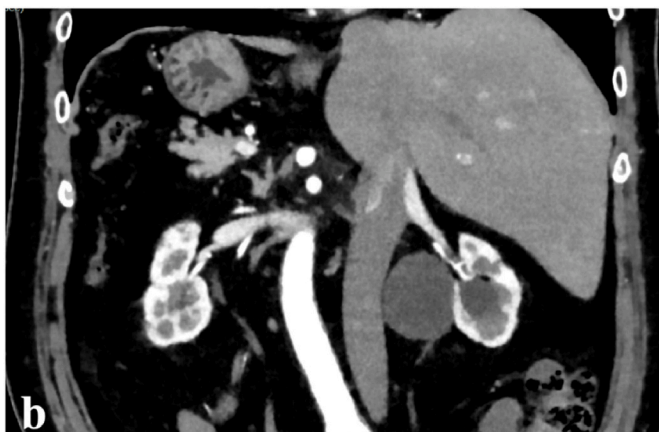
CT findings with 46mm exophytic renal mass at the left renal hilum and the complete SIT.
